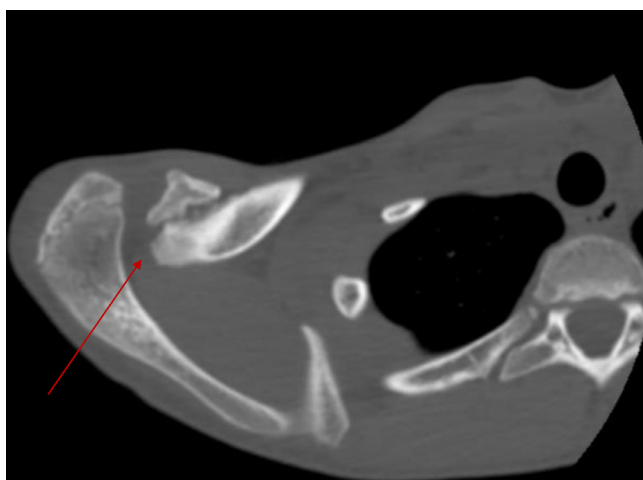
MRI scan of the clavicle.
